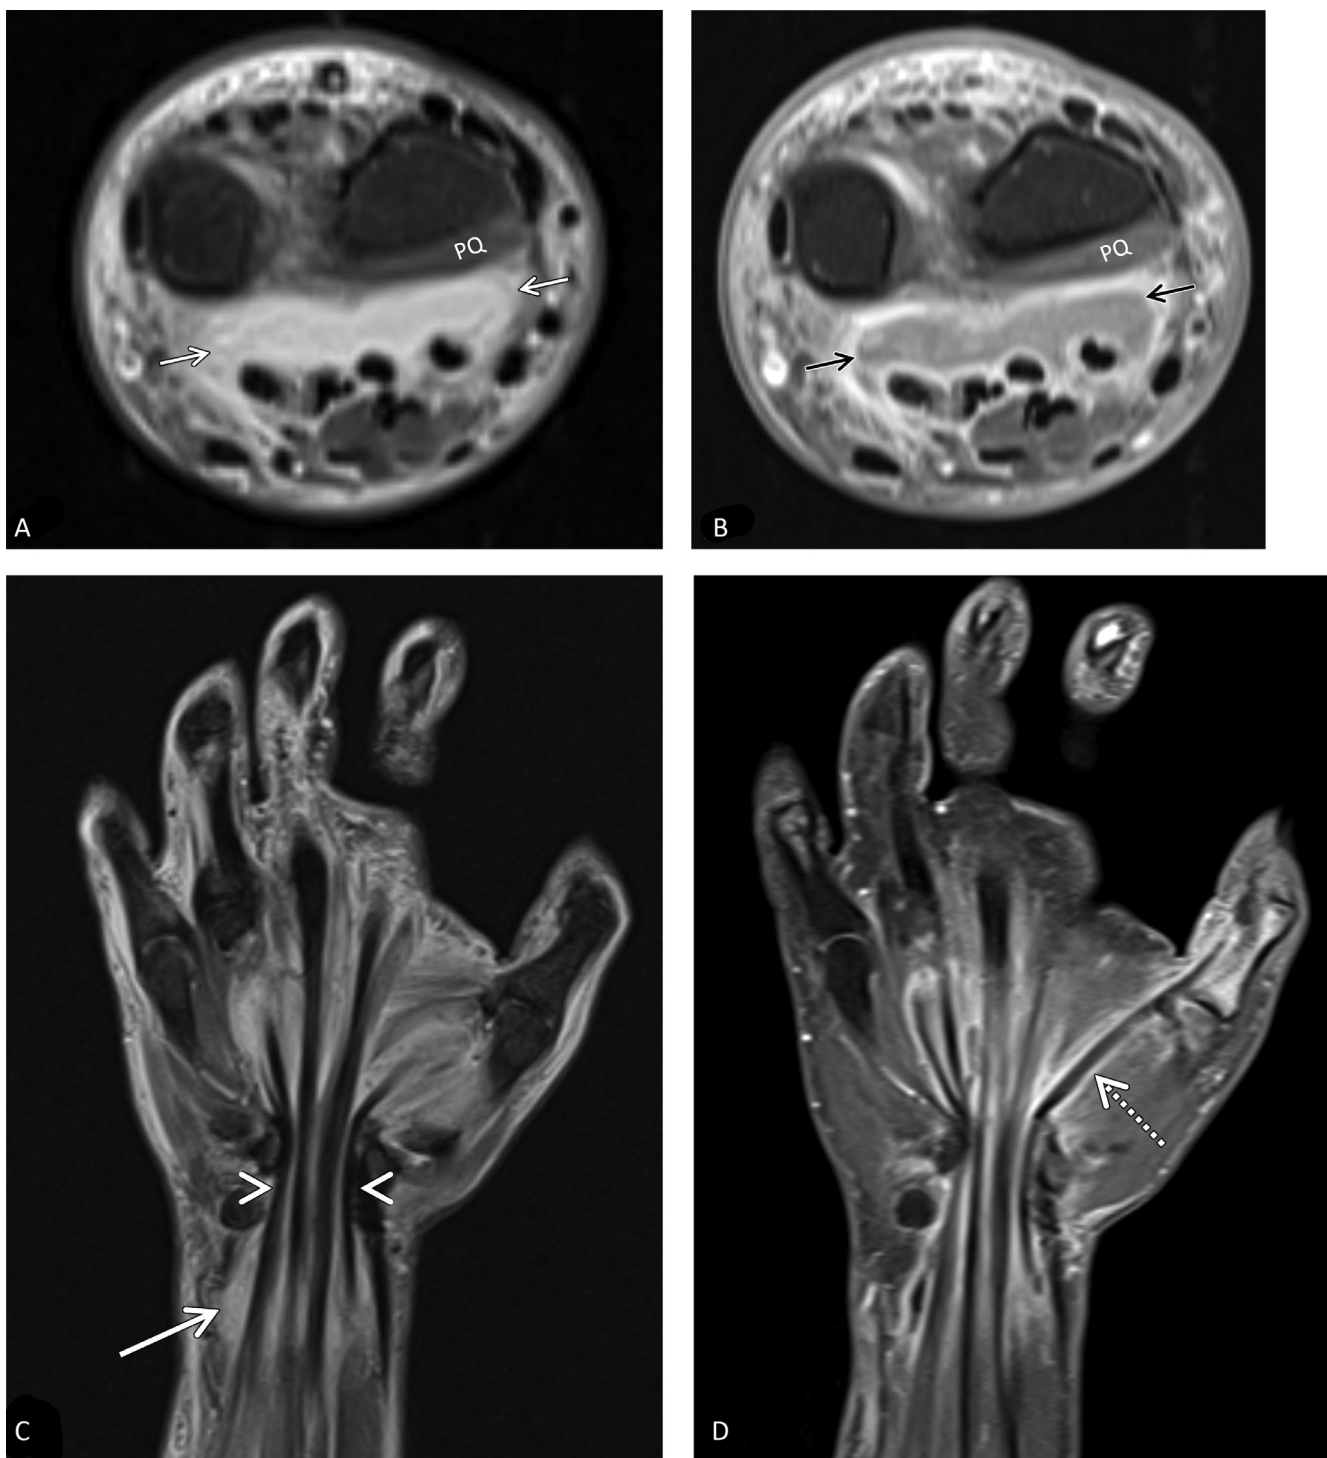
MRI of the left wrist. Axial (A) and coronal (C), fat-suppressed, T2-weighted sequences and axial (B) and coronal (D), post-contrast, fat-suppressed, and T1-weighted sequences are shown. A T2-weighted hyperintense collection with rim enhancement (between the arrows in A and B) is demonstrated at the volar aspect of the distal forearm between the deep flexor tendons and the pronator quadratus (PQ) muscle (space of Parona). The coronal images (C and D) show fluid and synovitis along the flexor tendon sheath of the thumb (dashed arrow in D) with extension through the carpal tunnel (between the arrowheads in C) and a resultant Parona space collection (arrow in C).
